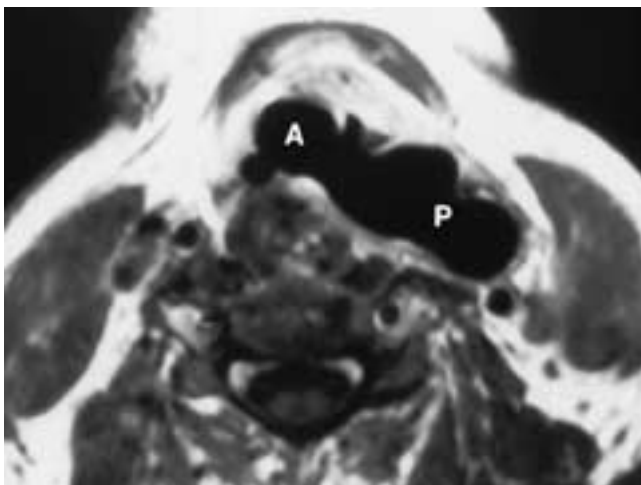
Axial noncontrast T1-weighted MR image shows marked dilatation of the lateral wall of the pharynx which is characteristic of a pharyngocele (P). Note the normal appearance of the airway (A).
